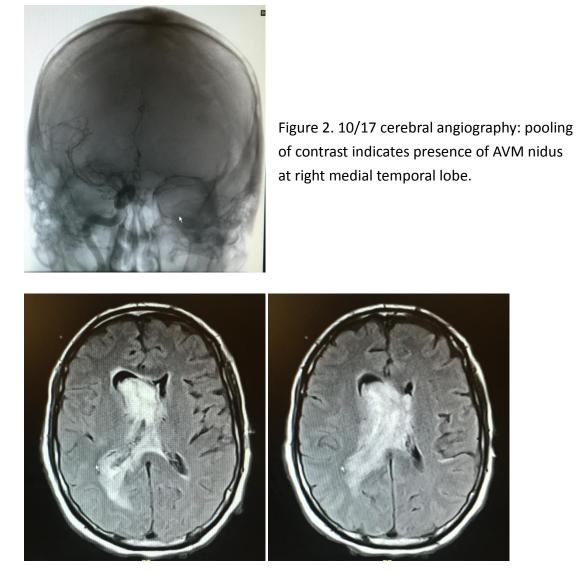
11/24 nonenhanced brain MRI shows AVM rebleed and progression of right
